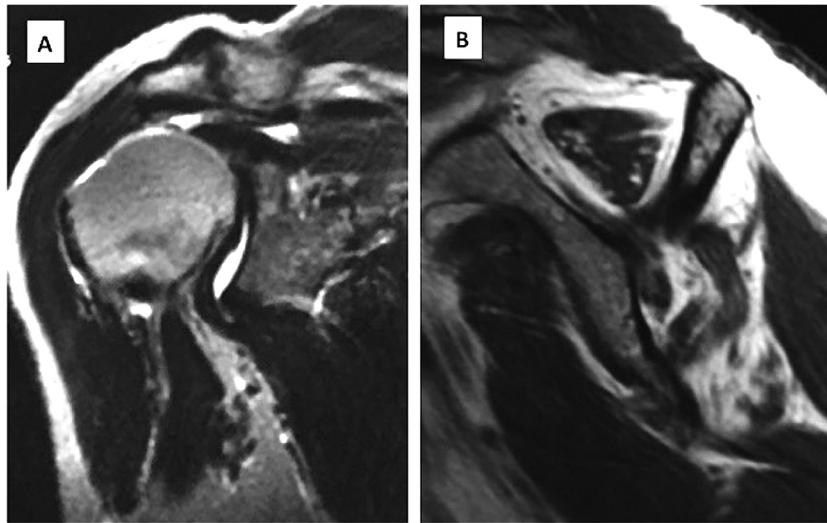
Typical magnetic resonance imaging of an isolated loss of active external rotation (ILER) patient. (A) Coronal view demonstrates massive irreparable rotator cuff tear with upward migration of humeral head. (B) Lateral oblique sagittal magnetic resonance image demonstrating atrophy and fatty infiltration of the supraspinatus, infraspinatus, and teres minor.
